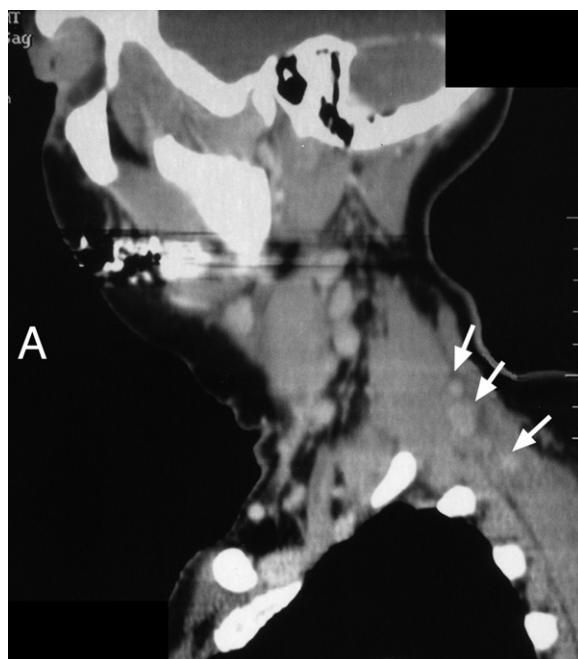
CT parasagittal image showing lymph node involvement at the cervico-thoracic region on the left side (arrows).
